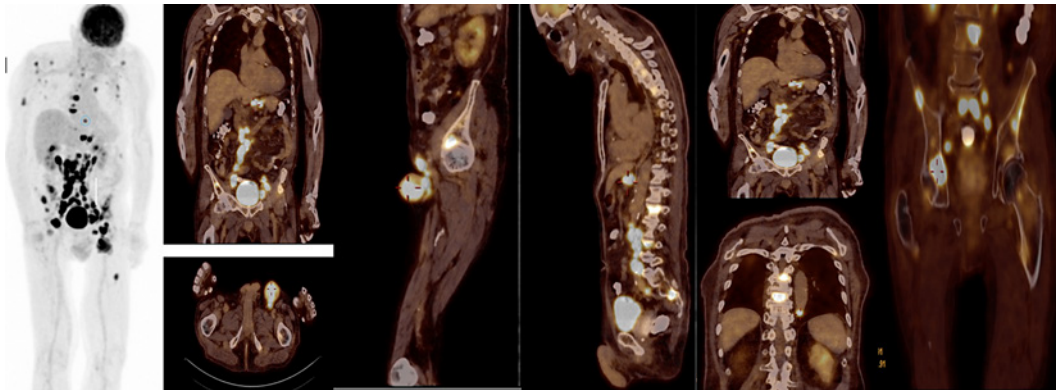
F-18 fluorodeoxyglucose positron emission tomography/CT showing increasing FDG uptake area in the left inguinal region (SUV = 7.7), the axial and peripheral skeleton, and supra- and infradiaphragmatic lymph nodes (SUV = 15.6).
